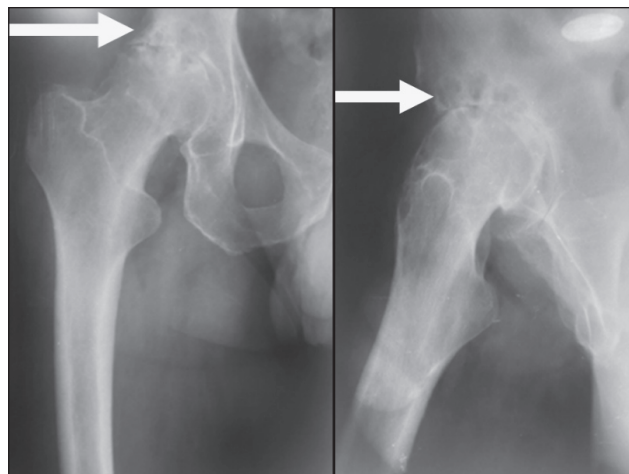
X-ray images of the right hip joint (noting cysts in the acetabulum)
